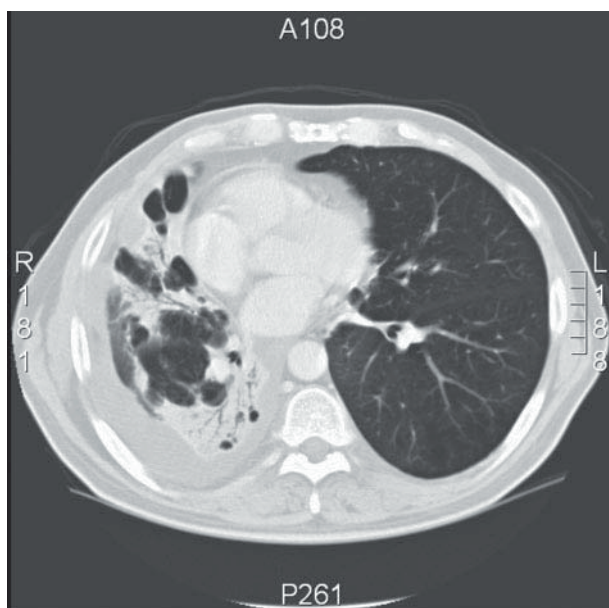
CT scan of the thorax demonstrating right middle and lower lobe peripherally based consolidation with a moderate-sized pleural effusion.
